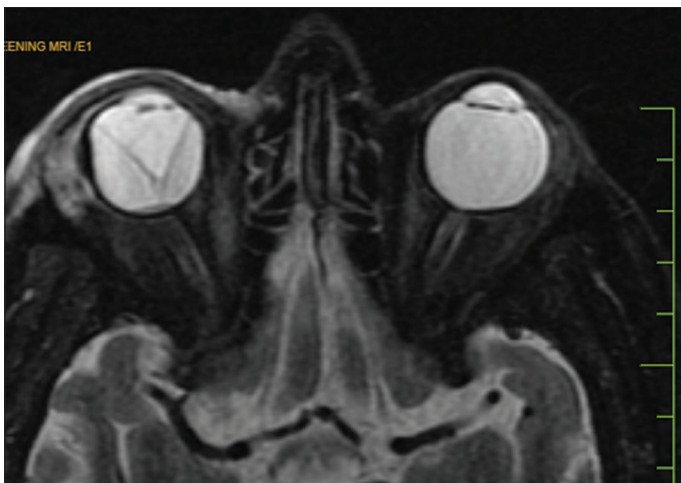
Initial magnetic resonance imaging orbit showing an ill-defined lesion in the right lateral peri-ocular region, molding the temporal surface of the globe from 6 to 2 o'clock, involving lacrimal gland and lateral rectus muscle, associated with retinal detachment
